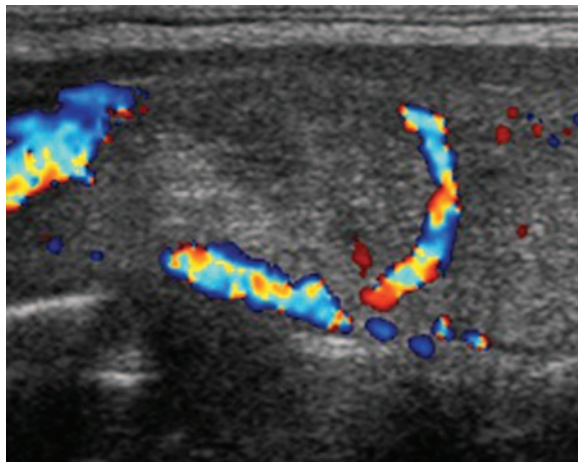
Follicular adenoma in a 36-year-old woman. Longitudinal color Doppler sonogram of the right lobe of the thyroid shows perinodular flow around a follicular adenoma.
